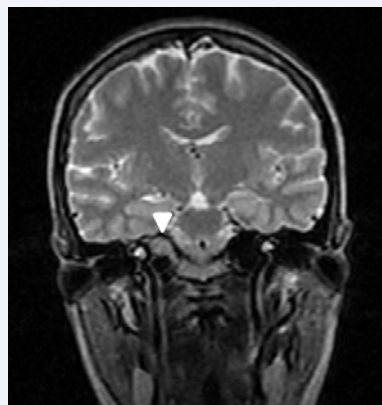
Preoperative MRI, coronal T2-W images, 9-mm hyperintense mass inside to the left IAC (arrowhead). Heterogeneously enhancing after contrast administration.
